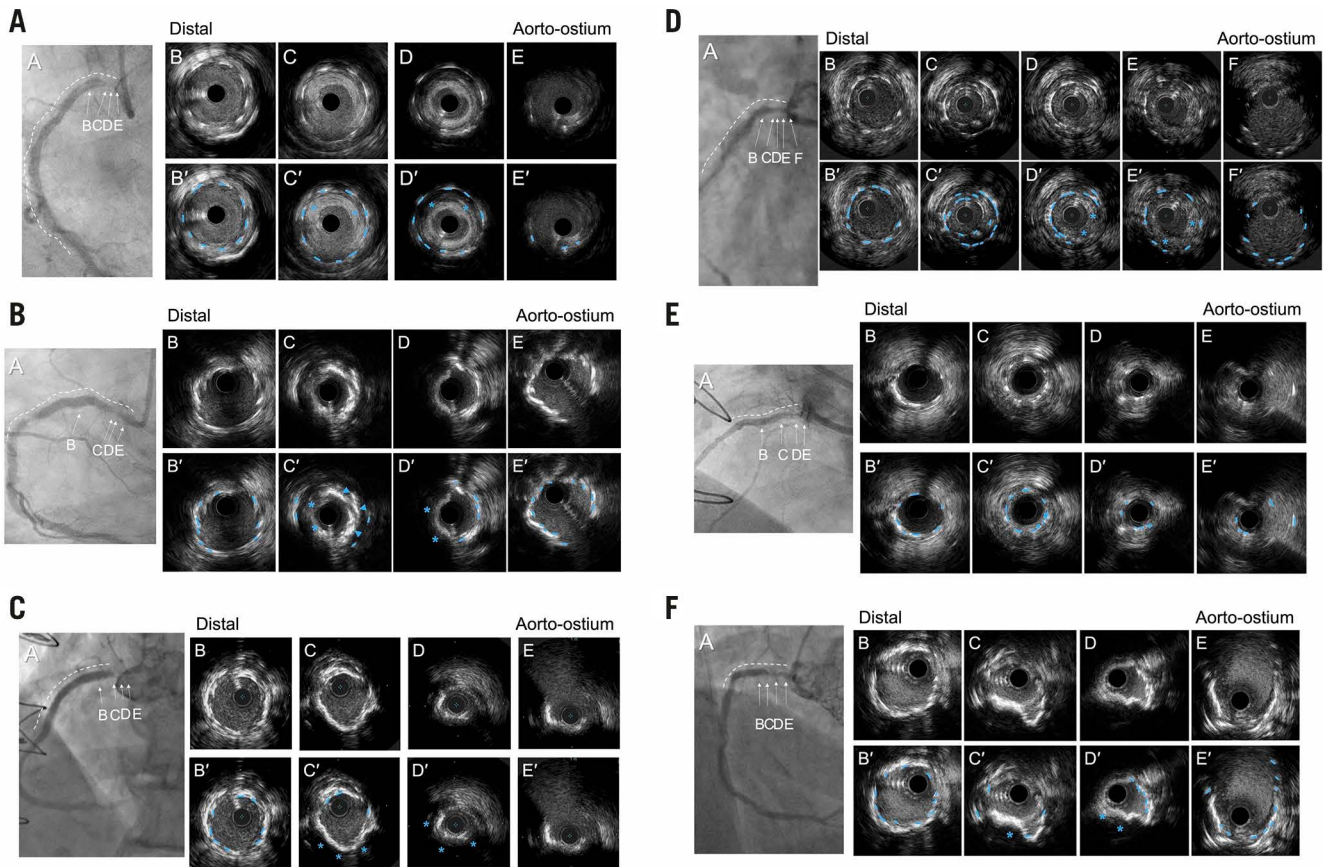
Representative cases for each pattern. In each example, the coronary angiogram at the time of ISR (A) is shown accompanied by a white dotted line indicating the old stents. B-E in the coronary angiograms correspond to the IVUS image (B-E). B'-E' are the same images with annotation compared with B-E. Blue dotted lines in the IVUS images indicate old stent struts. A) Excessive neointimal hyperplasia with good stent expansion; the blue asterisks indicate excessive neointimal hyperplasia. B) Neoatherosclerosis with good stent expansion; the blue arrowheads indicate neointimal calcium (superficial hyperintensity with acoustic shadow), and the blue asterisks indicate neointimal attenuated plaque (signal attenuation without calcium) representing lipidic plaque. These represent neoatherosclerosis within the old stent. C) Ostial restenosis without coverage of the ostium; the stent struts (blue dotted lines) were observed only in B and C with no struts in D and E indicating the lack of ostial stent coverage associated with a new stenosis. D) Overlap type stent fracture. Within a single-stent segment, 2 layers of old stent struts were observed (blue dotted lines) along with neointimal hyperplasia (blue asterisks). The inner stent layer measured 4.6 mm^2 in C, smaller than the distal non-fractured stent area (8.9 mm^2) in B. E) Underexpanded stent with minimal neointimal hyperplasia. A severely underexpanded stent (minimum stent area = 2.2 mm^2) at D compared to the distal segment (stent area of 5.2 mm^2) in B. Neointimal hyperplasia at D measured 43%. F) Protruding calcified nodule within the stent. A calcified nodule (blue asterisks) was observed within the old stent struts (blue dotted lines) without adjacent neointimal hyperplasia. ISR: in-stent restenosis; IVUS: intravascular ultrasound
